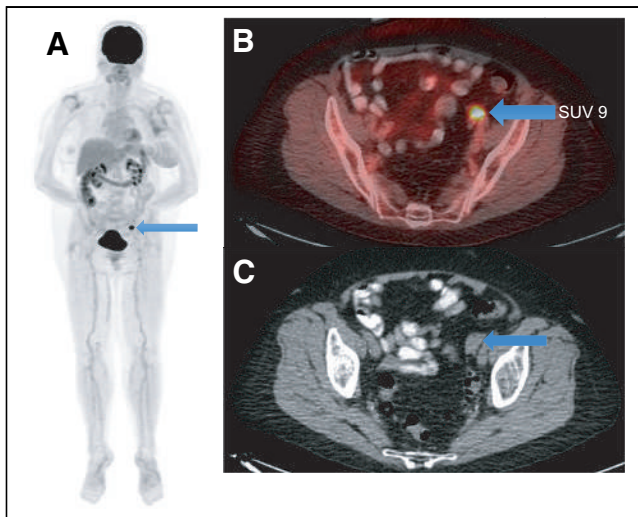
Asymptomatic 70-y-old woman with left arm MCC (s/p excision, left axillary lymphadenectomy, radiation to axilla) underwent surveillance ^{18}F -FDG PET/CT scan 3.3 mo after treatment. ^{18}F -FDG PET/CT (A; maximum-intensity projection, arrow) scan revealed solitary focal ^{18}F -FDG uptake in left pelvis (B; fused PET/CT, SUV 9, arrow) in a nodular soft-tissue-density lesion in left adnexa (C; axial CT, arrow). USG pelvis showed solid mass in left ovary measuring 1.8 x 1.4 x 1.6 cm, corresponding to site of abnormality on ^{18}F -FDG PET/CT. Patient underwent salpingo-oophorectomy and pathology was positive for MCC. s/p = status post; USG = ultrasound.
